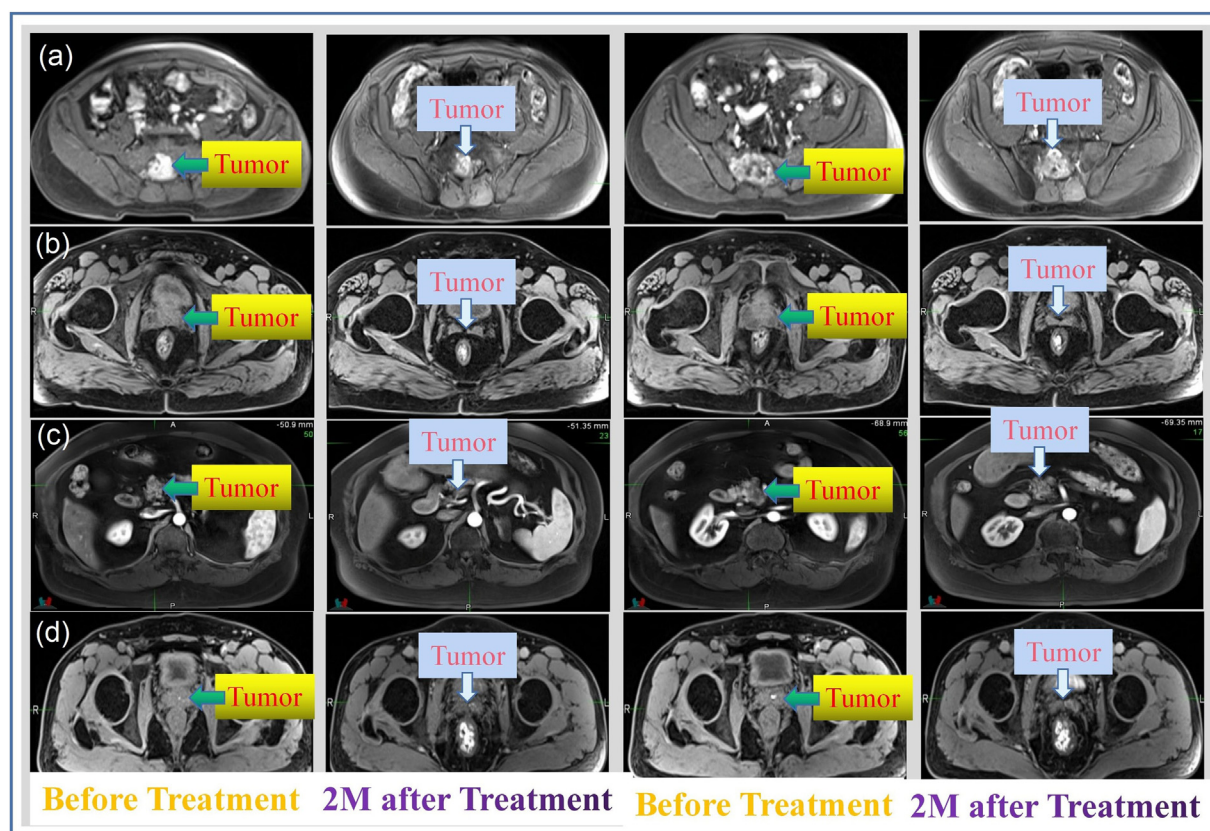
Four participants underwent magnetic resonance imaging scanning 2 months after spot scanning delivery. (a) Schwannoma at sacrum case; (b) prostate cancer case; (c) pancreatic head carcinoma case; and (d) prostate cancer case. The tumors exhibited significant regression, and no adverse effects such as bleeding, ulceration, necrosis, or perforation of the small intestine were observed after treatment.
